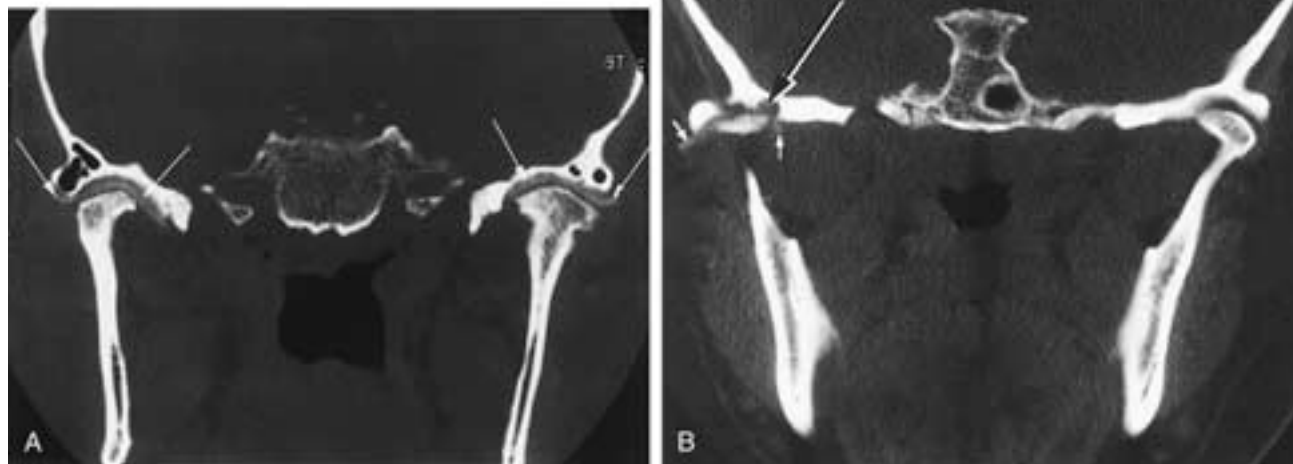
A, Coronal CT scan of a patient with bilateral Proplast Teflon implants (*arrows*) in good condition. There is no evidence of erosions into the middle cranial fossa, and the implants appear intact and with a good relationship to the condyle and glenoid fossa. B, Erosions of the glenoid fossa secondary to an alloplastic implant. Coronal CT scan of another patient with a Proplast Teflon implant (*short arrows*) and erosions of the glenoid fossa (*long arrow*). Also note that the implant is difficult to outline due to partial fragmentation.
